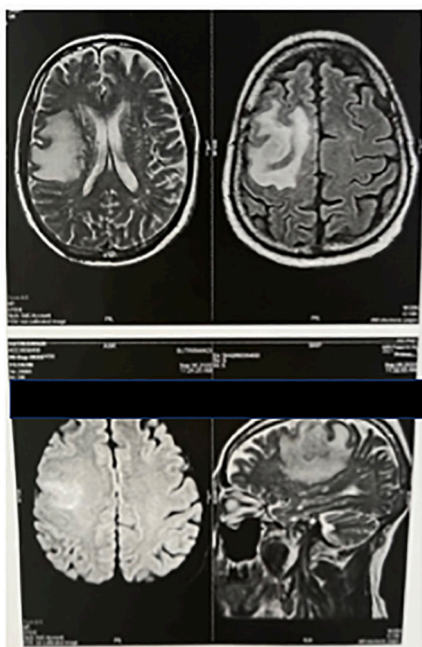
Contrast enhancement in the right subcortical frontoparietal lobe seen on brain MRI.
